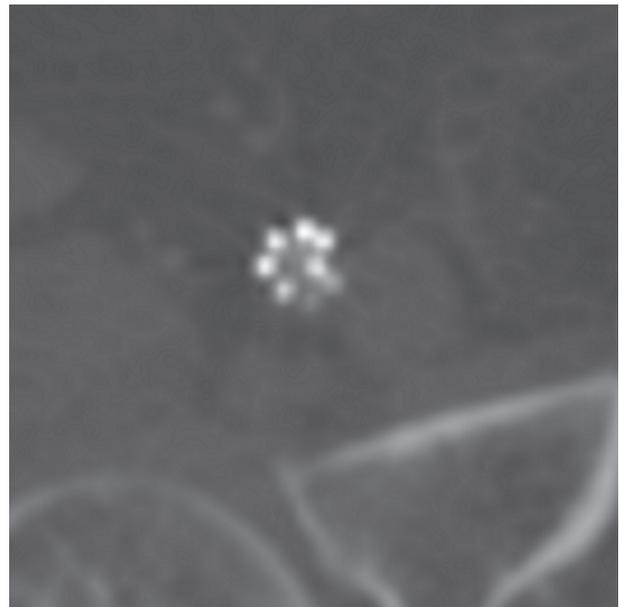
Computed tomography angiography of the right common femoral artery. Beam hardening artefacts at the distal stent part obstruct lumen analysis
